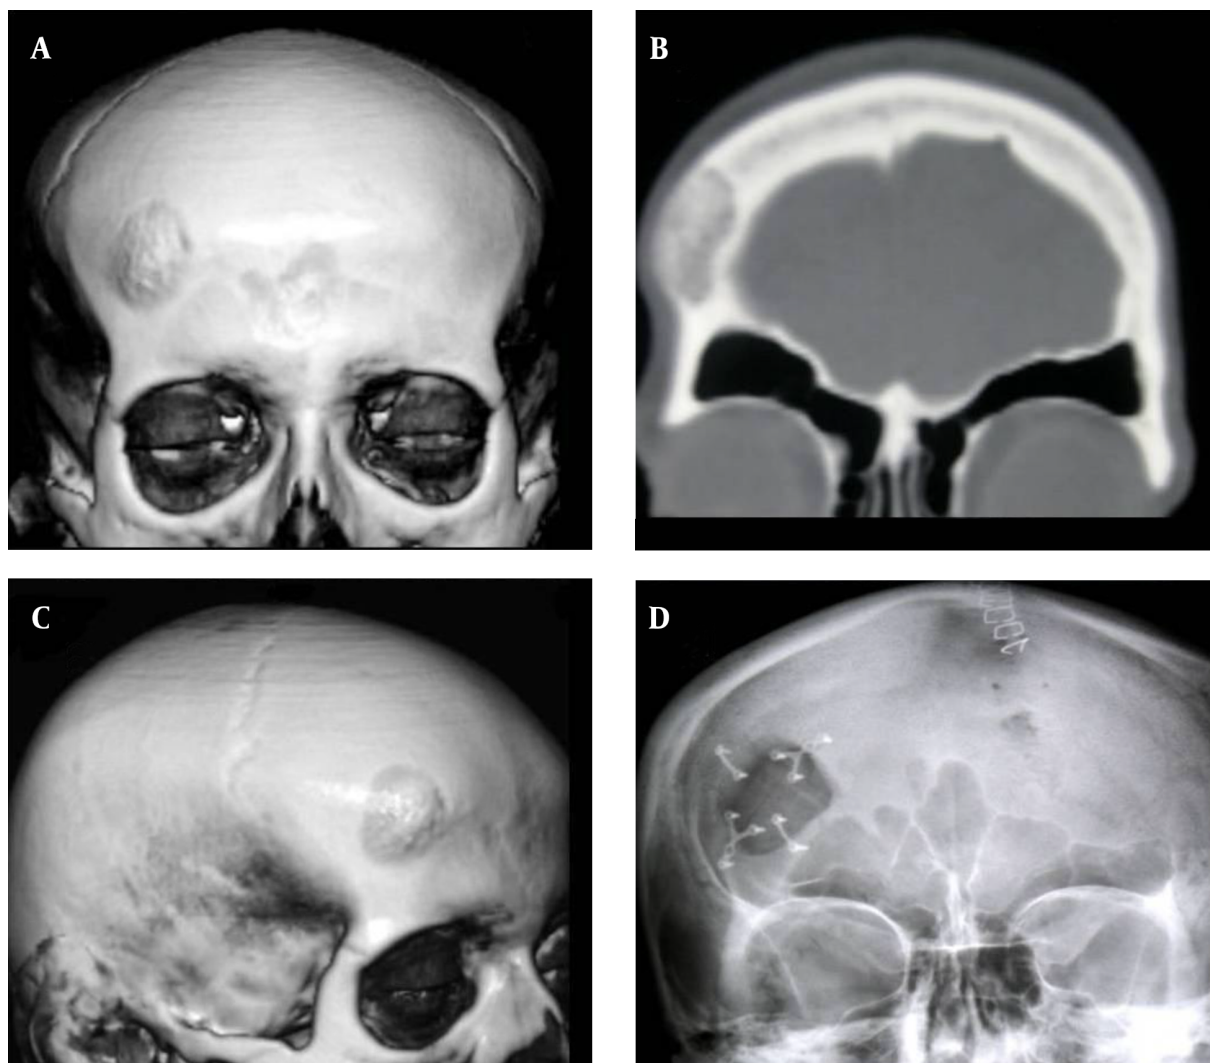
A, C, the Preoperative X-ray Image of the Case; B, in the CT of the coronal brain, an osteoma is observed on the edge of the right frontal sinus; D, the images of post-operative direct radio-image.
